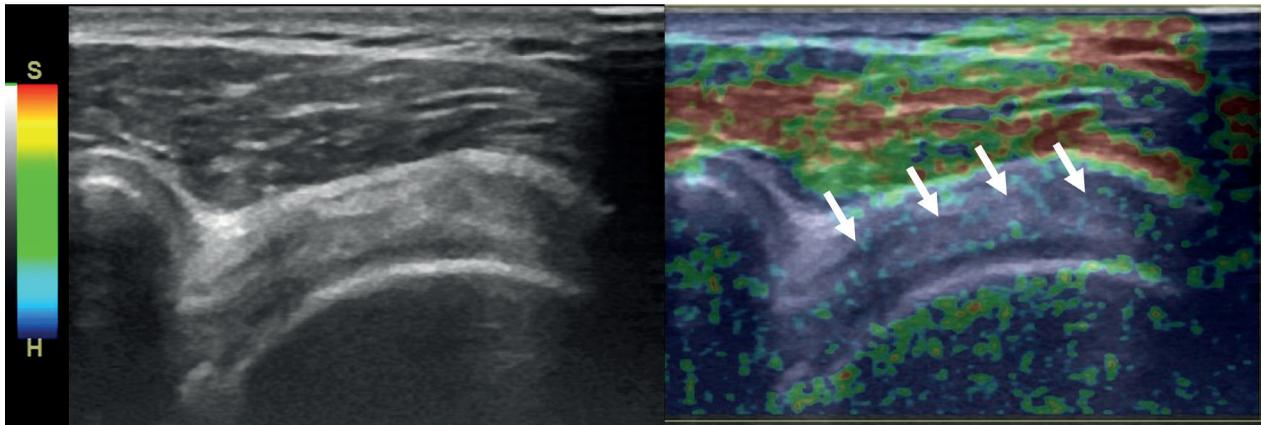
Normal sonographic and sonoelastographic appearance of the supraspinatus tendon (arrows). On the grey-scale ultrasound, the tendon is homogeneously hyperintense with smooth contours. The supraspinatus tendon exhibits predominantly blue with some green coloration on the sonoelastography, indicating its hard tissue characteristics.
